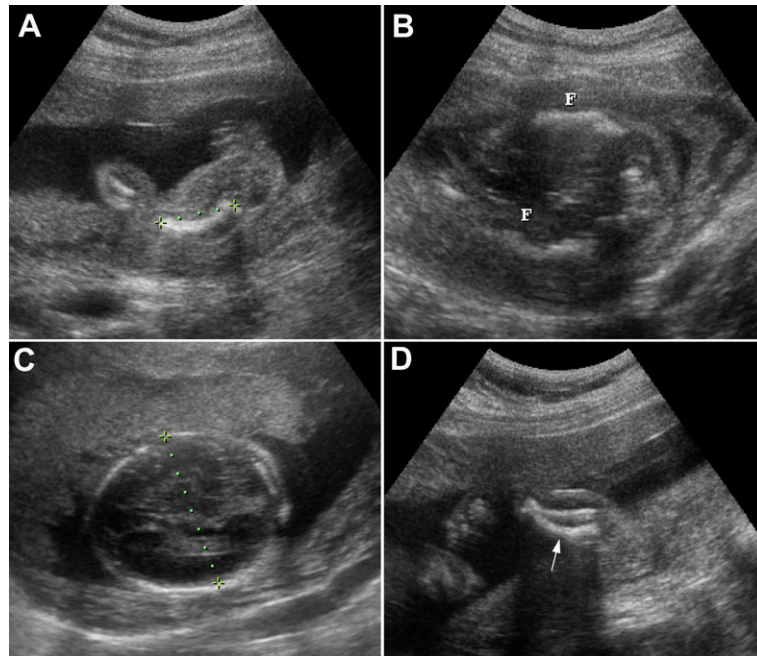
Prenatal ultrasound at 22 weeks of gestation shows (A) curved femur, (B) curved femurs, (C) hypomineralization of the skull and (D) curved tibia (arrow). F = femur.
